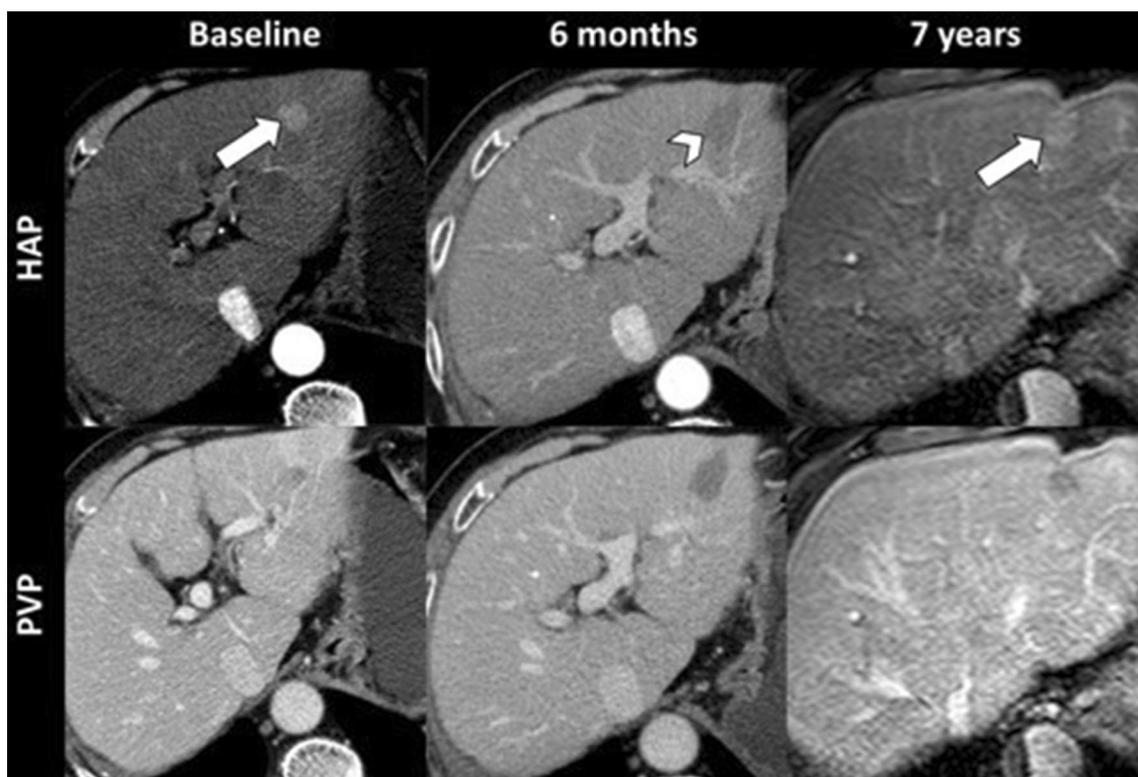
83-year-old man with HCV cirrhosis. Baseline, 6-months and 7-years follow-up CT and MR images obtained on hepatic arterial (HAP, upper row) and portal-venous (PVP, bottom row) phase. Baseline CT demonstrated a nonrim arterial phase hyperenhancing lesion (arrow) with washout on portal-venous phase. The lesion underwent
